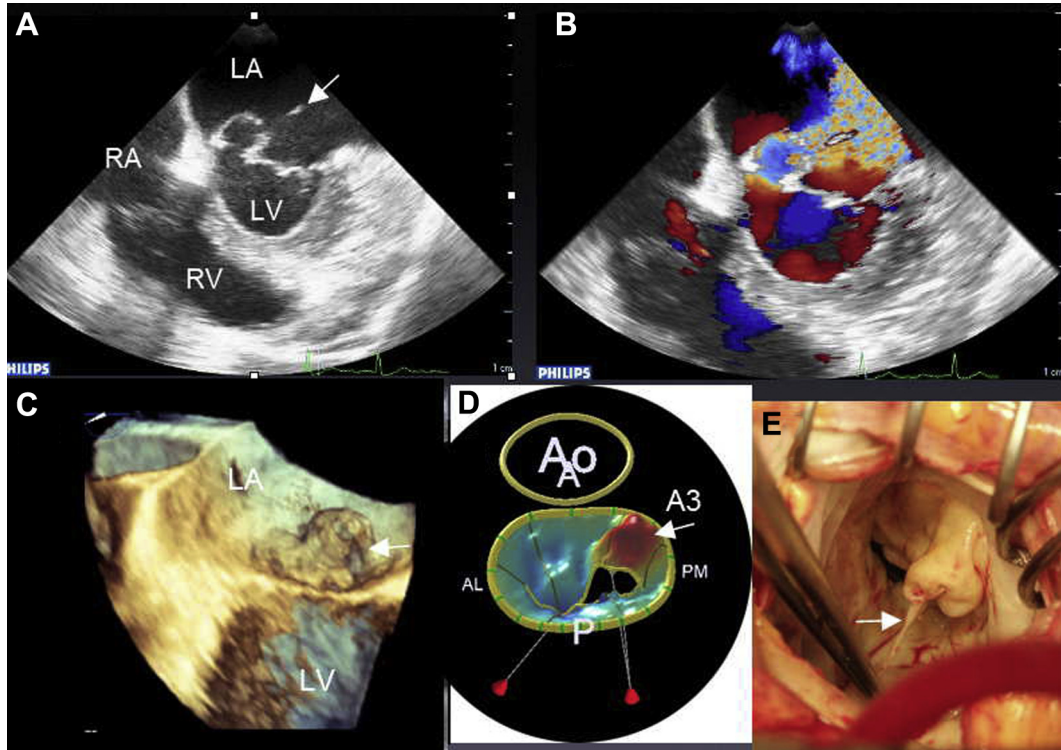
Mitral regurgitation. (A) Four-chamber apical view of a two-dimensional (2D) transesophageal echocardiography (TEE) demonstrates anterior leaflet prolapse with ruptured chordae (arrow); (B) color Doppler apical four-chamber view shows severe mitral regurgitation with the regurgitant jet hitting the distant wall of the left atrium and encircling it, as well as traversing back into the pulmonary veins; (C) 3D TEE demonstrates the height of the A3 flail (arrow); (D) prolapse of A3 is reconstructed mitral valve using Mitral Valve Quantification software (MVQ) (Advanced Quantification Software version 7.1, Philips Ultrasounds, Bothell, WA); and (E) surgeon's view: A3 cord is visualized (arrow). Ao = aorta; LA = left atrium; LV = left ventricle; RA = right atrium; RV = right ventricle.
